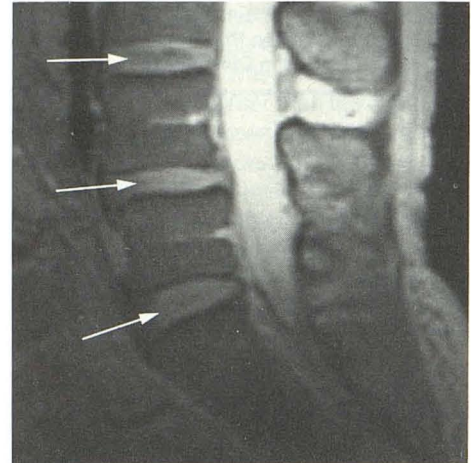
MR image (2500/75) shows dark bands (arrows) in lumbar disks not explained by truncation artifact. These bands, thicker and coarser than truncation artifacts, represent so-called "intranuclear cleft" (phase direction anterior-posterior,  $128 \times 256$  matrix).
